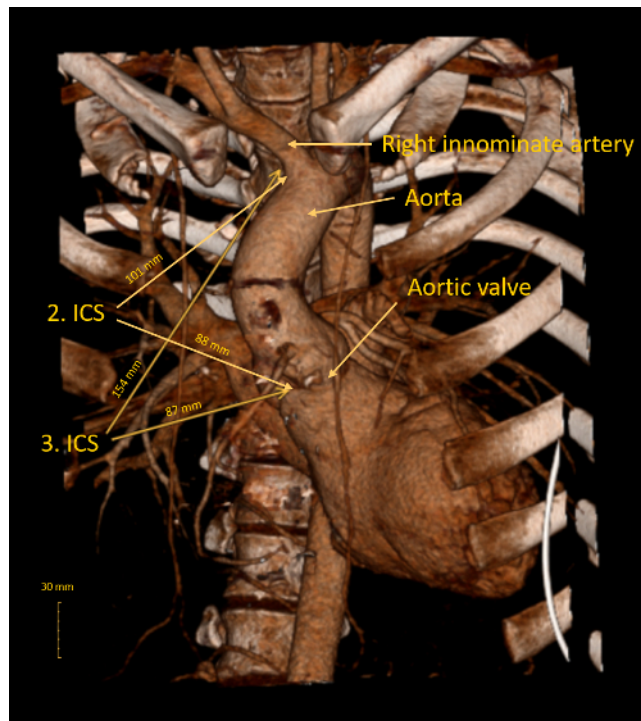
3-D chest CT reconstruction for pre-operative planning. Measurements from the mid-clavicular line to the aortic cannulation site (origin of the right innominate artery) and to the aortic valve of the second and third intercostal spaces (ICS) are reported on this image (1 mm in scale = 2.9 mm). In this case, the second ICS is chosen for incisional approach of the mini-thoracotomy while with comparable distances to the aortic valve, the distance to the cannulation site is shorter for the second compared to the third ICS. [Please click here to view a larger version of this figure.](#)
